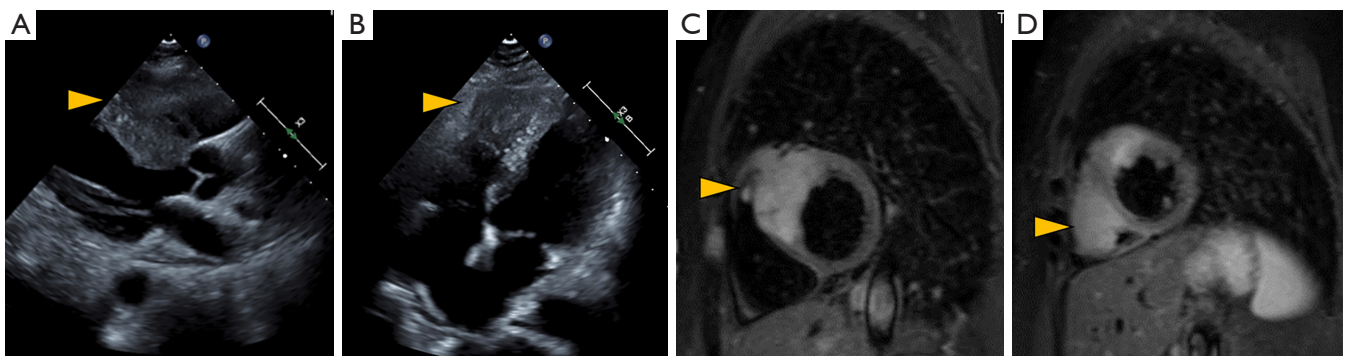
Cardiac metastasis imaging. (A,B) Echocardiography. (C,D) T2-weighted magnetic resonance imaging of cardiac metastasis. Arrows indicate metastatic lesions in the left ventricular septum (A,C) and right ventricular apex (B,D).
